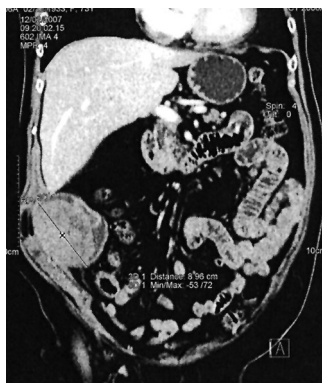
CT scan of the abdominal wall mass in the right lower abdomen protruding into the abdominal cavity dislocating small bowel loops.
